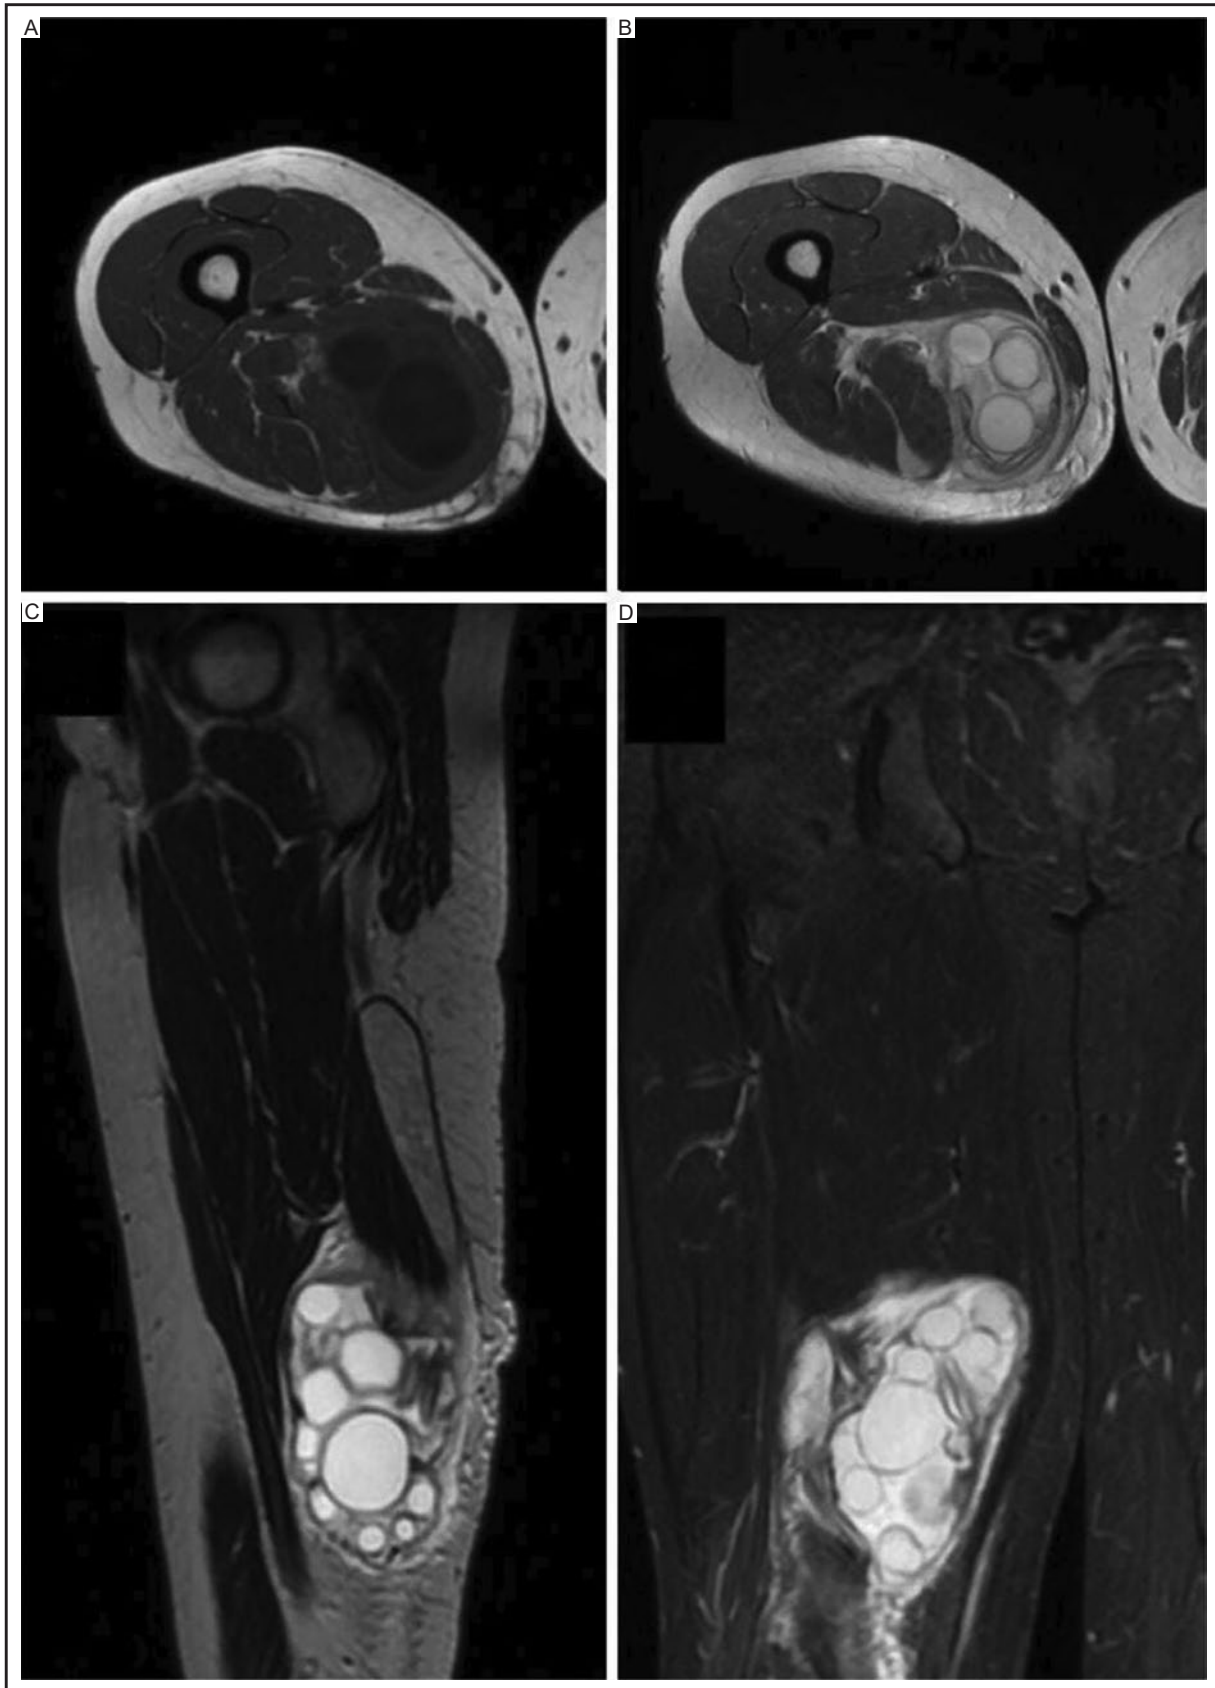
MR imaging of a 44-year-old patient with a deformity of the right thigh. A: multicystic lesion with T1 hypointensity. B: PD moderate signal intensity. C: T2 hyperintensity. D: STIR hyperintensity.
